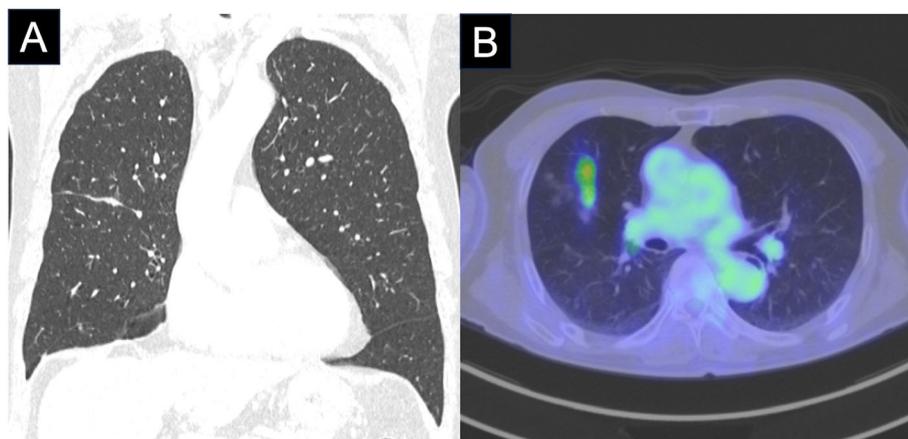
Findings from preoperative computed tomography (CT) and positron emission tomography-CT of the chest. (A) Chest CT shows pleural thickening along the right interlobar fissure and an uneven border with the lung. (B) Positron emission tomography-CT shows a series of point and nodular accumulations of ^{18}F -fluorodeoxyglucose (maximum standardized uptake = 2.8) along the pleural thickening. These findings are consistent with lung cancer and pleural dissemination. No ^{18}F -fluorodeoxyglucose accumulation suggestive of lymph node metastasis or distant disease is apparent.
